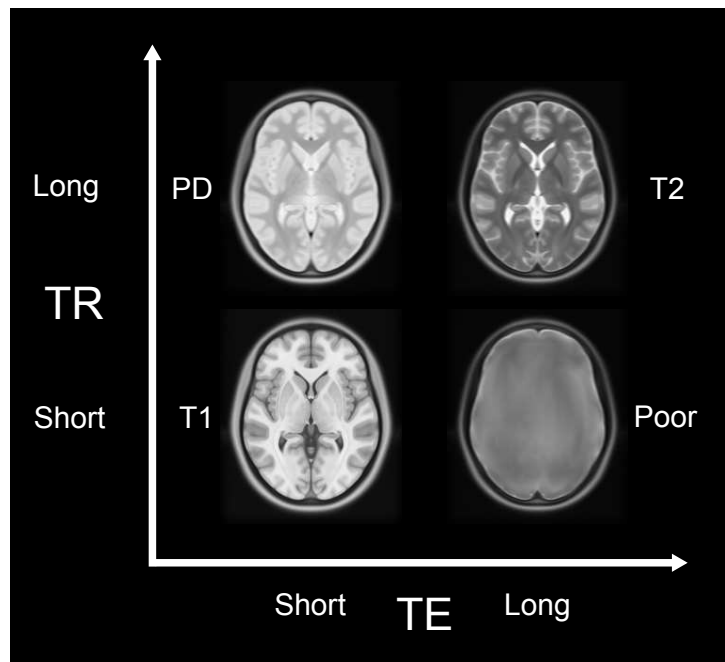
Relation between short and long TR and TE and the contrast obtained in MR images.
